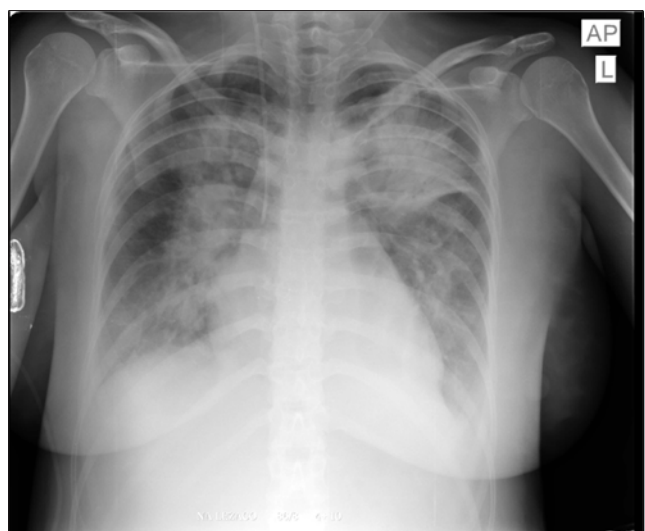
The X-ray shows extended, mottled, blending density affecting both lungs, probably as a result of inflammation
